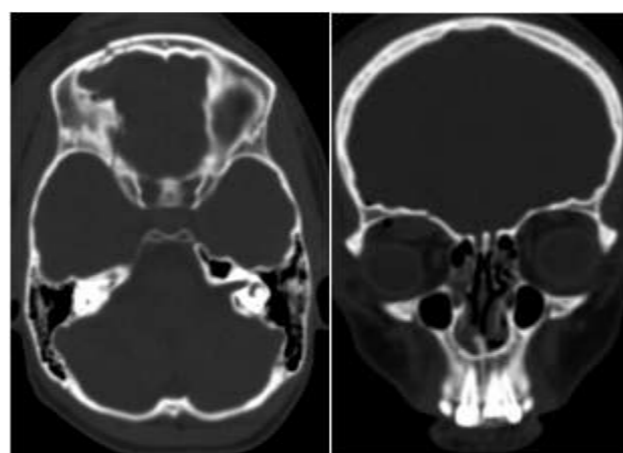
(Left) Axial CT brain bone window showing fracture of the right frontal bone and right orbital roof. (Right) Coronal CT brain bone window shows fractured right orbital roof in a 16-year-old female patient presented with raccoon eye after a fall from height.
